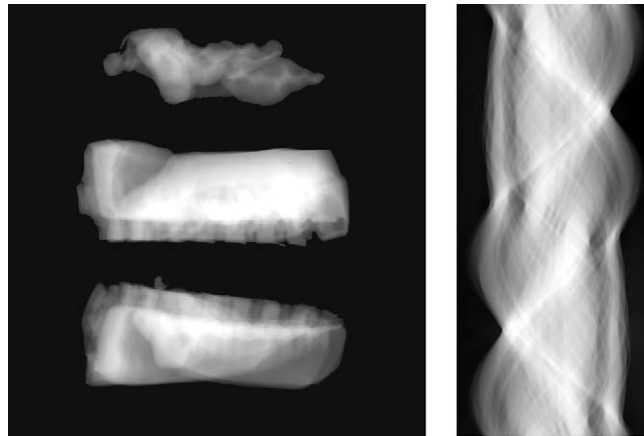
A, CT-generated radiographs of PVS bite registration projected onto stone model (*top*), upper PVS impression (*middle*), and lower PVS impression (*bottom*); B, sinogram.
